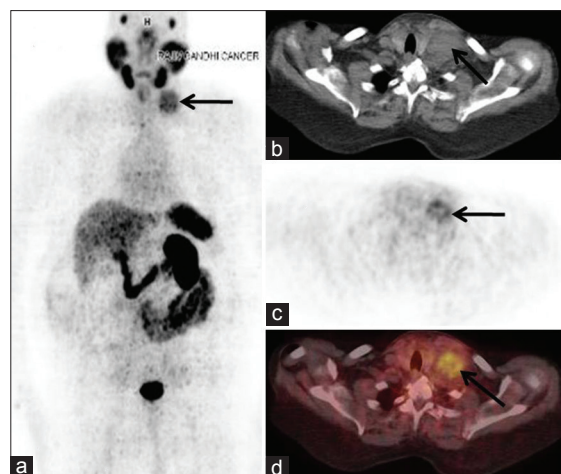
Ga-68 prostate-specific membrane antigen positron emission tomography-computed tomography scan, (a) maximum intensity projection; (b) axial computed tomography; (c) axial positron emission tomography; (d) fused positron emission tomography-computed tomography: Images show prostate-specific membrane antigen avid enlarged left supraclavicular lymphnode (black arrow)
